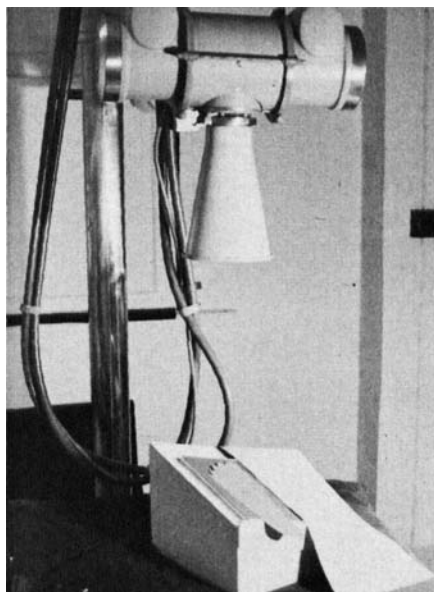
Device for APO view showing head of radiographic machine, position of cassette and lead cover.
